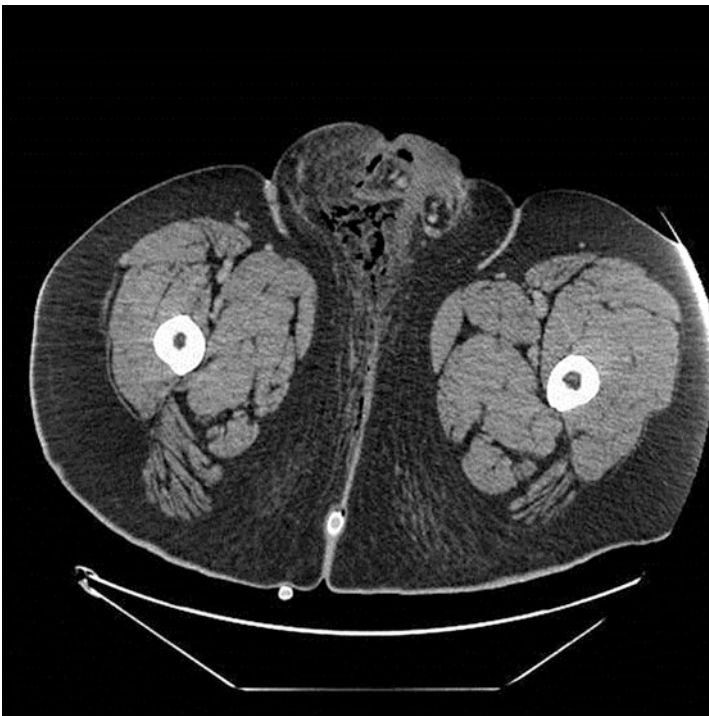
CT scan showing gas gangrene in the scrotum. This is consistent with Fournier's gangrene. © Dale Dangleben, MD
